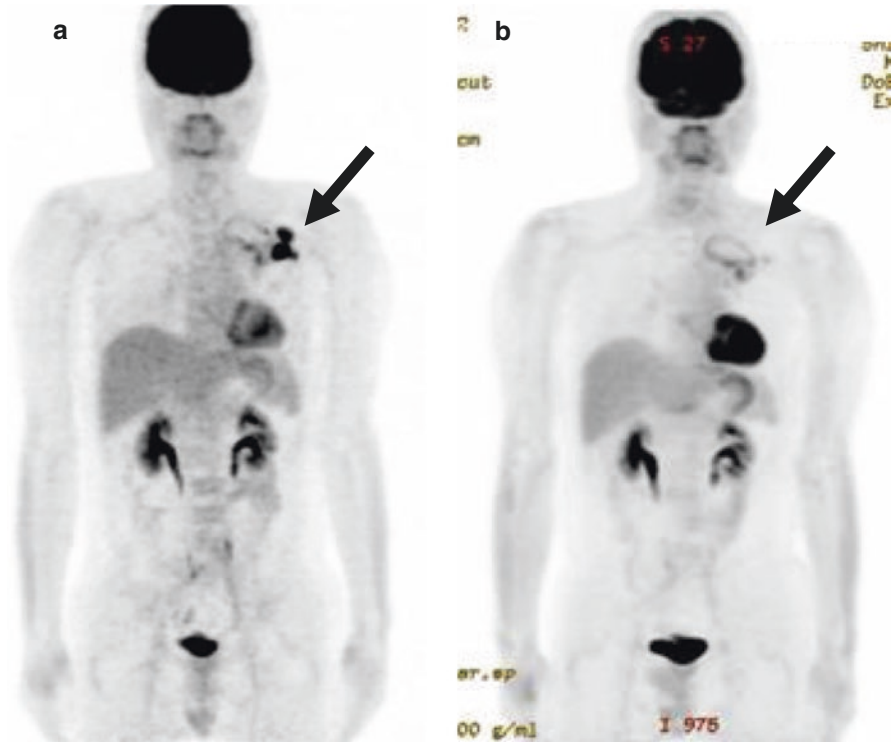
A 48-year-old male with pulmonary adenocarcinoma who was treated with nivolumab as ninth-line treatment. PET imaging shows markedly decreased uptake of FDG in lymph node metastasis (black arrow) between before (a) and after 1 month (b) from nivolumab initiation. The values of SUV_{max} in the metastatic lesion before and after nivolumab are 17.1 and 1.9, respectively
